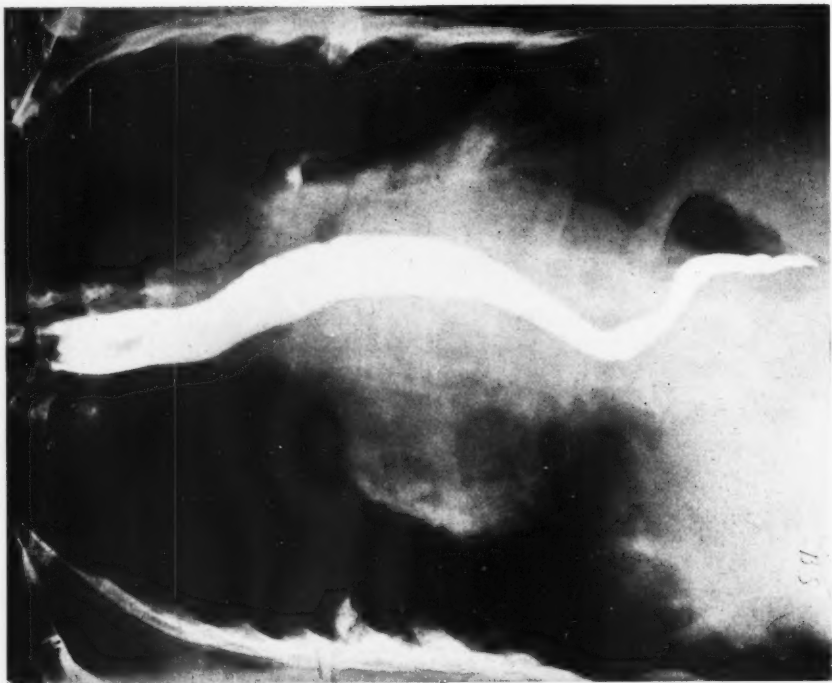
Case 6. High-penetration postero-anterior radiograph showing an enlarged left auricle and displacement of the barium-filled oesophagus to the left. The oesophagus appears to follow the course of the descending aorta.
